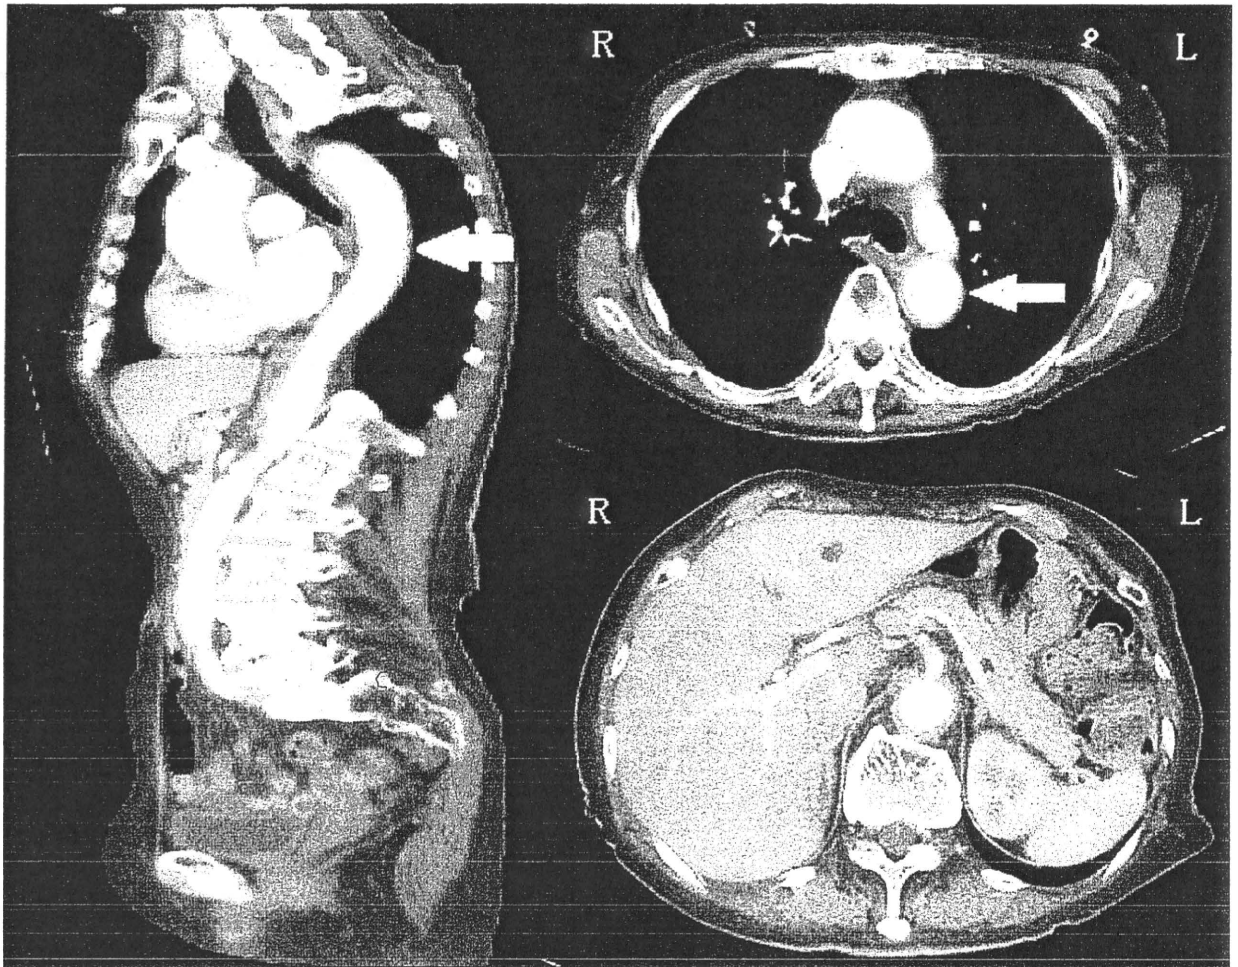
Contrast-enhanced computed tomography (CT) image. Contrast-enhanced CT of the chest and abdomen showed thickening of the wall of the thoracic descending aorta to the abdominal aorta and both common iliac arteries, and delayed contrast enhancement of these arteries. None of the aortic branches was stenosed.
